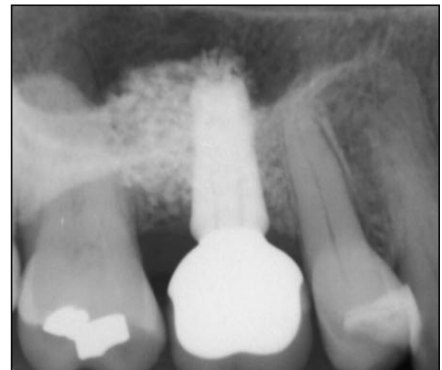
Tatum type sinuslift performed with PTG. Five years control radiograph. Compliments of Dr. Hans Bystedt.
